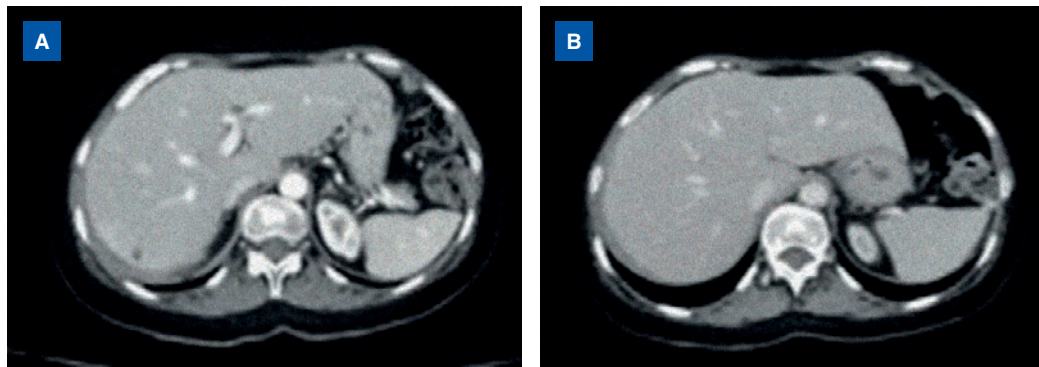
CT Scan. A: March 2017: progression of the disease. Perihepatic implants + ascites. B: July 2017: partial response. Perihepatic implants.
